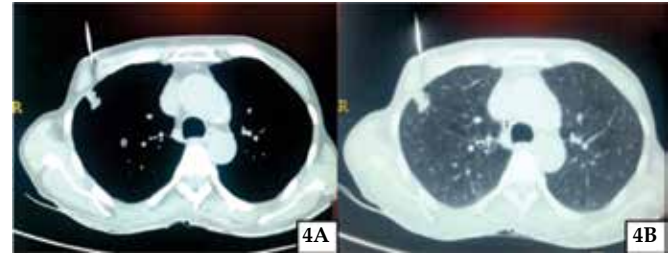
(A, B). Computed tomography (mediastinal and lung window cut) of the chest showing the presence of core needle guard with stylet in the lung mass lesion through chest wall.
